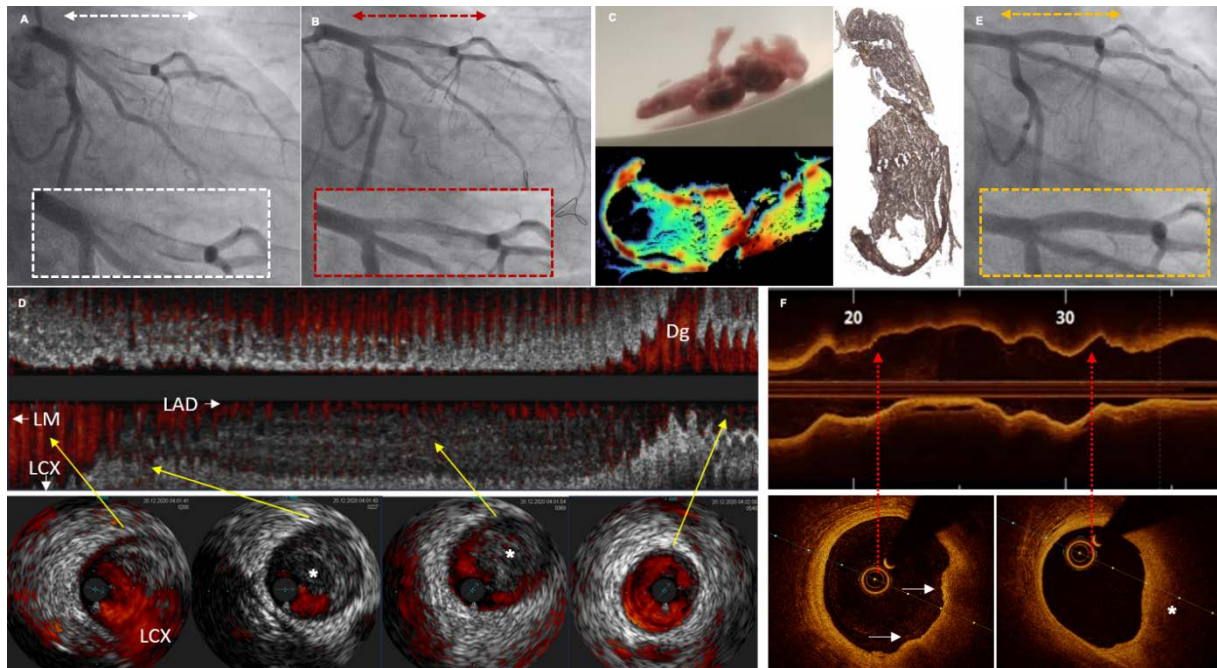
Multimodality assessment of patient with ST-segment myocardial infarction successfully treated with non-stenting strategy. Baseline coronary angiography with haziness in proximal left anterior descending artery (A) and angiography after thrombectomy (B). C. Aspirated thrombus with results of Fourier and Raman Spectroscopy. D. Intravascular ultrasound imaging with plaque in proximal part of LAD covered by thrombus protruding to medial LAD (asterisk). E. Control angiography and optical coherence tomography (F) with thrombus (the arrow) and lipid plaque (asterisks)
